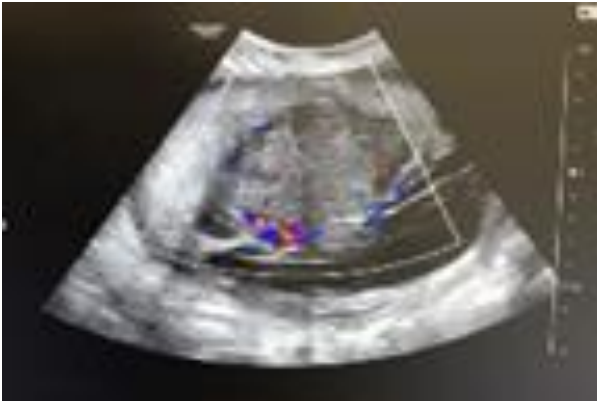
Ultrasound image of chorioangioma near the cord insertion.
